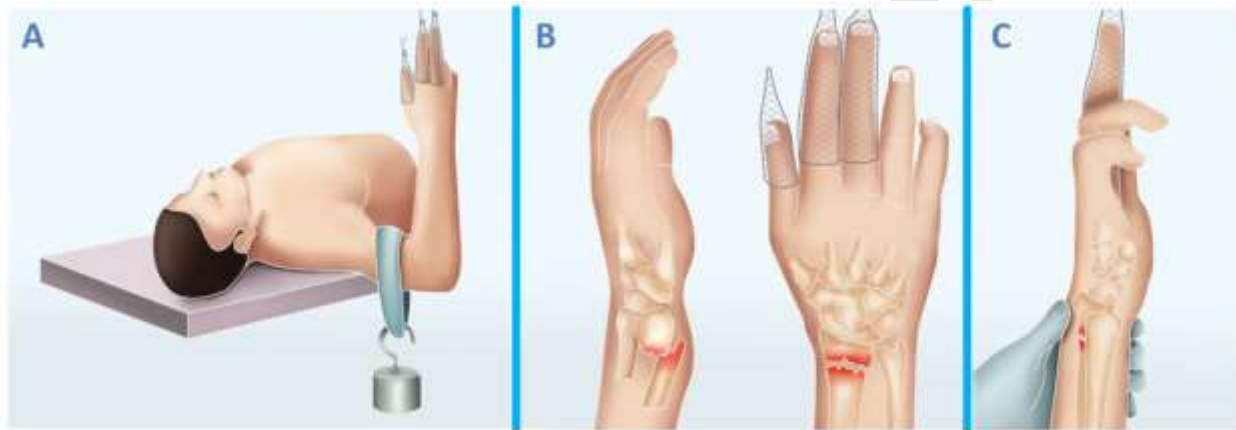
The most widely accepted immobilisation position for distal radius fractures with dorsal deviation is with the wrist flexed 15° and ulnarly deviated 10°. This slight volar and ulnar deviation generated during the reduction manoeuvre causes the intact dorsal periosteal bridge to tighten and stabilise the fracture using the tension band principle (A, B). Charnley's three-point support concept is used to stabilise the fracture (C). Figure 5. Conservative treatment performed in cases of distal radius fracture with minimal displacement, with less than two millimetres of radial shortening and less than 5° of dorsal tilt. The wrist was immobilised for four weeks with a plaster cast, leaving the elbow free. Radiographs on the day of injury (A), at 30 days (B), and at six months (C). Gr.4.
